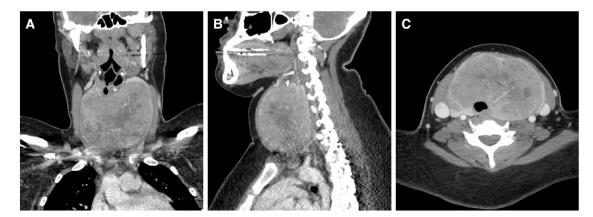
Computed tomography imaging of the neck with intravenous contrast revealed a massive heterogeneously enhancing thyroid goiter. Asymmetric enlargement of the left thyroid lobe is evident in the coronal imaging plane (A). The extent of thyroid enlargement can be further appreciated in the sagittal plane (B). Rightward tracheal deviation due to the asymmetric left thyroid lobe enlargement was observed on transverse imaging (C).
